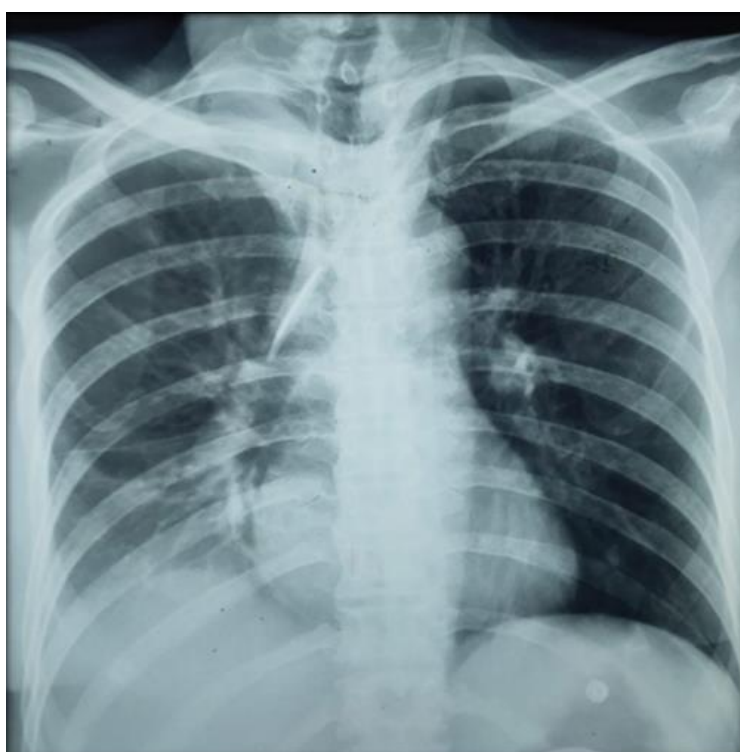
Control chest X-ray showing resorption of right pleural fluid
